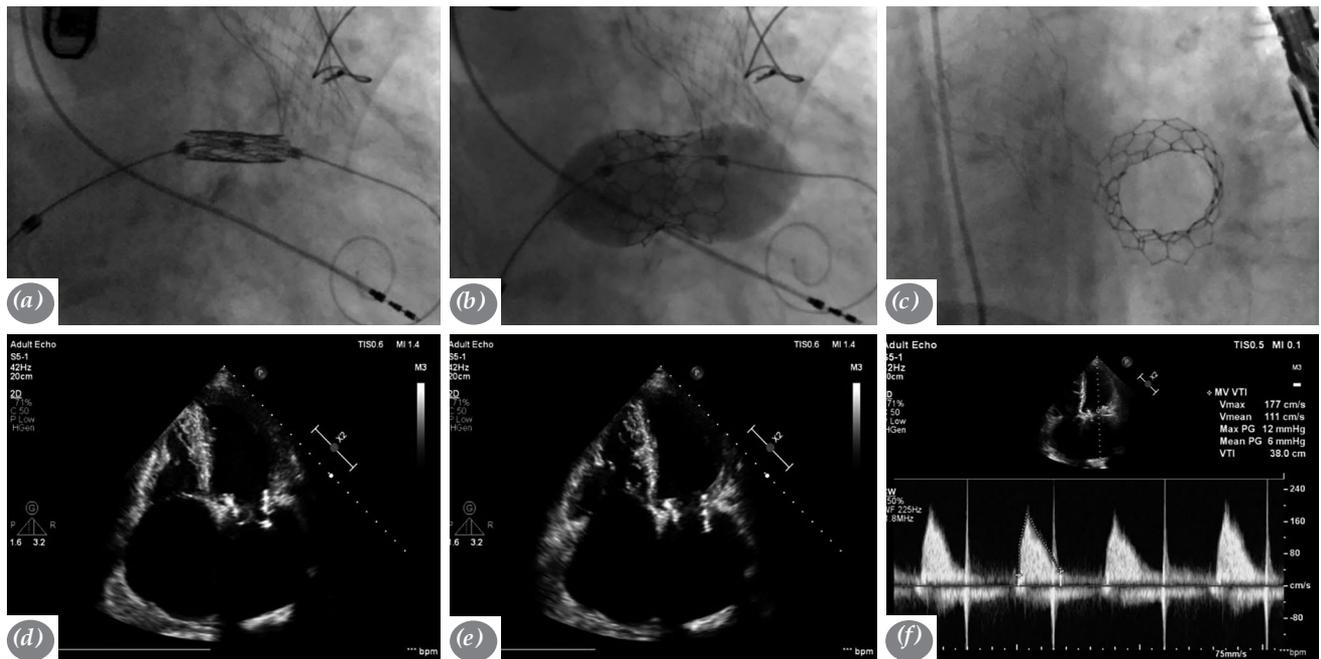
Post-procedure images. (a) The crimped Myval valve was positioned within the ring of the old bioprosthetic mitral valve through a transeptal approach. (b) Balloon expansion of the Myval valve in the bioprosthetic mitral valve. (c) Fluoroscopy showing successful ViV replacement in the mitral position. (d) Well-functioning mitral valves after ViV deployment in systole and (e) diastole. (f) Six-month follow-up transthoracic echocardiography showing a mitral valve area of 1.83 cm² and transaortic gradient valve mean gradient of 4 mmHg.
